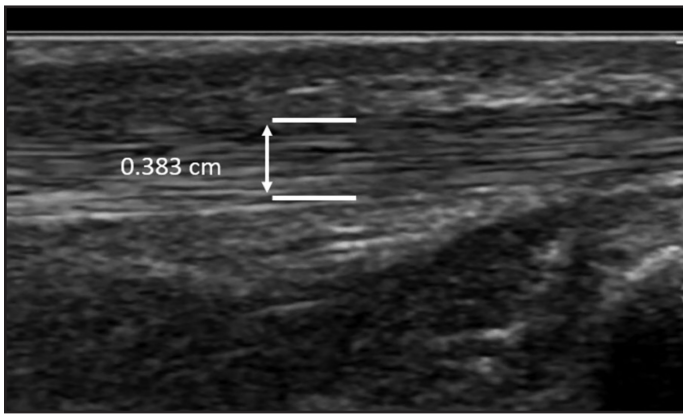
Sonographic Image of Athlete 2's Left Patellar Tendon (Posttest). Tendon thickness increased to 0.383 cm from 0.358 cm at baseline.
